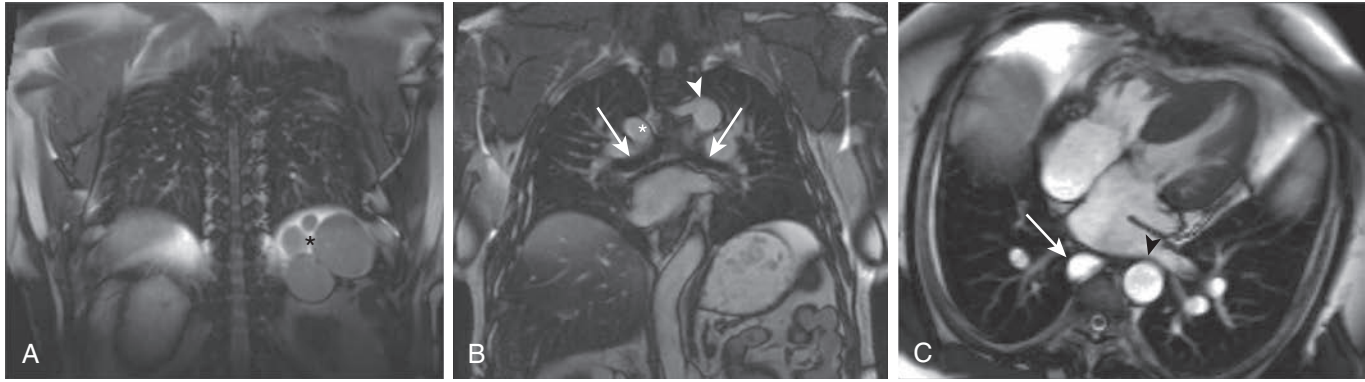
Magnetic resonance imaging in a patient with isomerism of the left atrial appendage. A, Coronal view revealing polysplenia (asterisk). B, Note bilateral left bronchi (white arrows), large azygos arch on right (asterisk), and anomalous origin of right subclavian artery from descending aorta (white arrowhead). C, Four-chamber view during systole showing repaired partial atrioventricular septal defect (AVSD), azygos vein on right (white arrow), and descending aorta on left (black arrowhead).
